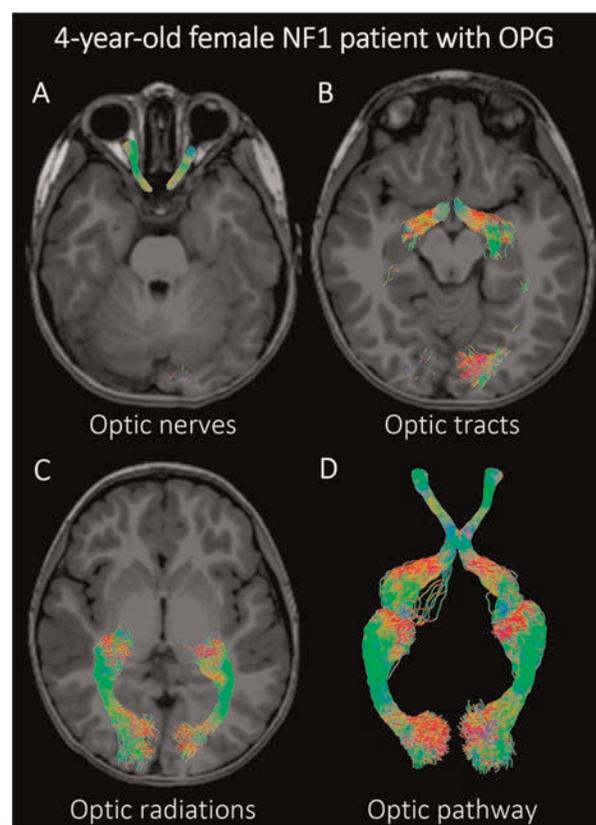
Tractography of the visual pathway. The streamlines from our automated tractography of the left and right optic nerves (A), optic tracts (B), and optic radiations (C) are overlaid on a T1-weighted image of a representative child with NF1 with optic pathway glioma (OPG). (D) 3D tract rendering of all three parts of the visual pathway of the same representative child. Red, green, and blue colors correspond to the diffusion RGB-color map and represent the direction of maximum diffusivity: red = left-right, green = anterior-posterior, blue = superior-inferior. Abstract PL 1-6
